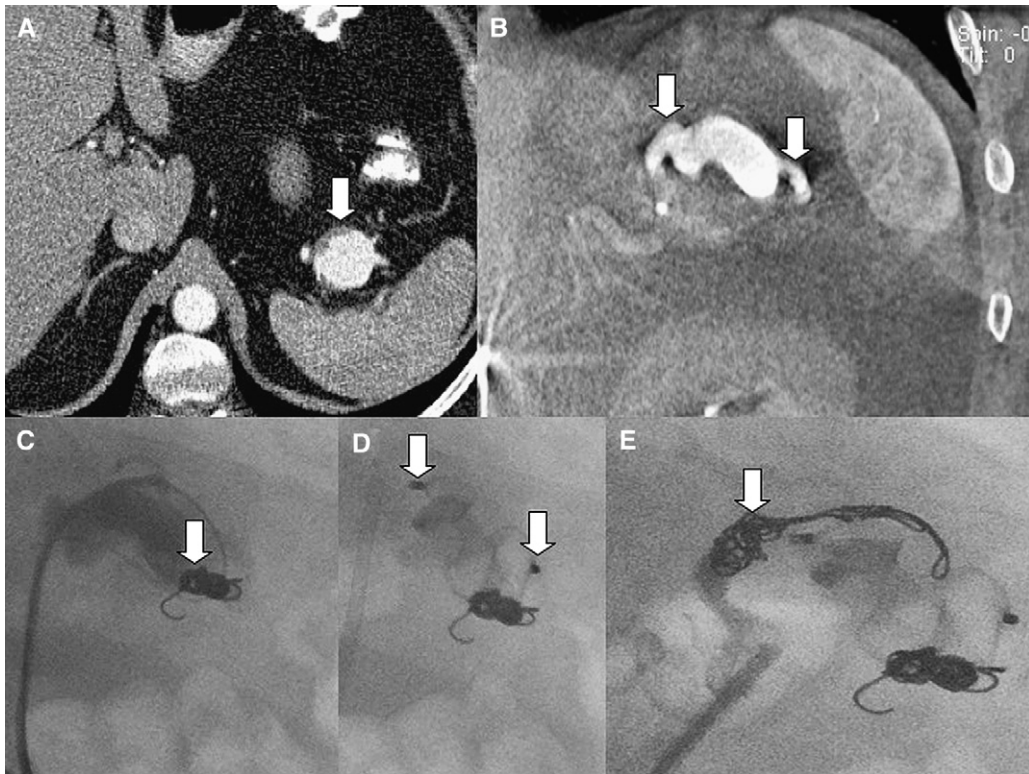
(A–E) Computed tomographic angiography (axial view) revealed the 3.6-cm prehilum splenic artery aneurysm (arrow in [A]). Cone-beam computed tomography (coronal view) documented extent of the aneurysmal sac, and the afferent and efferent arterial segment of the splenic artery (arrows in [B]). Embolization was performed in a 3-step approach. First the arterial “back door” was occluded by using two 6 mm-diameter/14 cm-length nester coils (arrow in [C]). Second, the aneurysmal sac was occluded by using a 22 mm-diameter/18 mm-length Amplatzer vascular plug II (arrows in [D]). Third, the afferent “front door” was occluded by using two 8 mm-diameter/14 cm-length nester coils (arrows in [E]).
